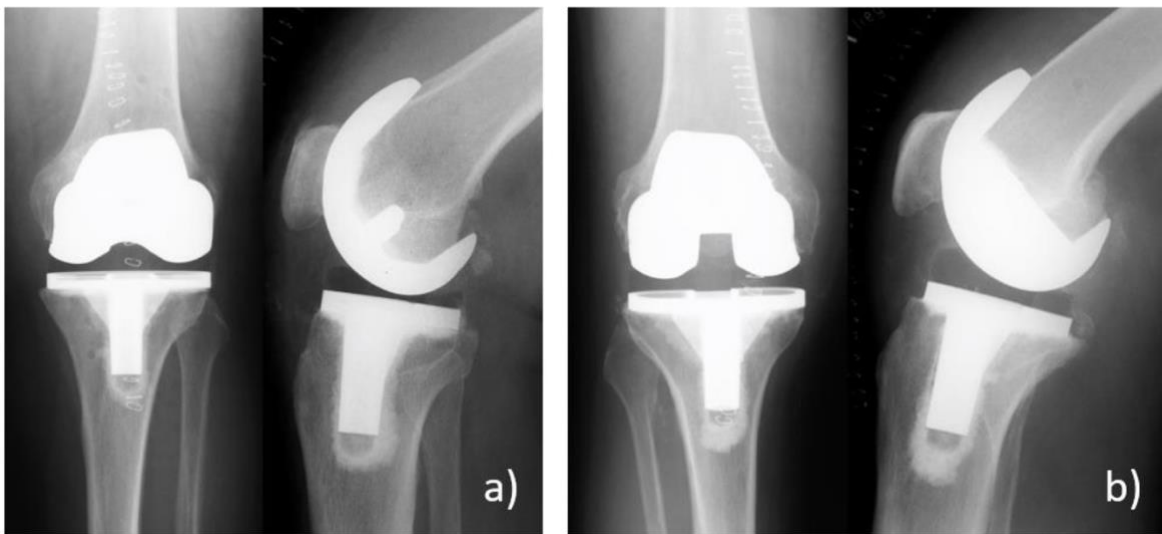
X-ray bicondylar knee prostheses cemented (36)
